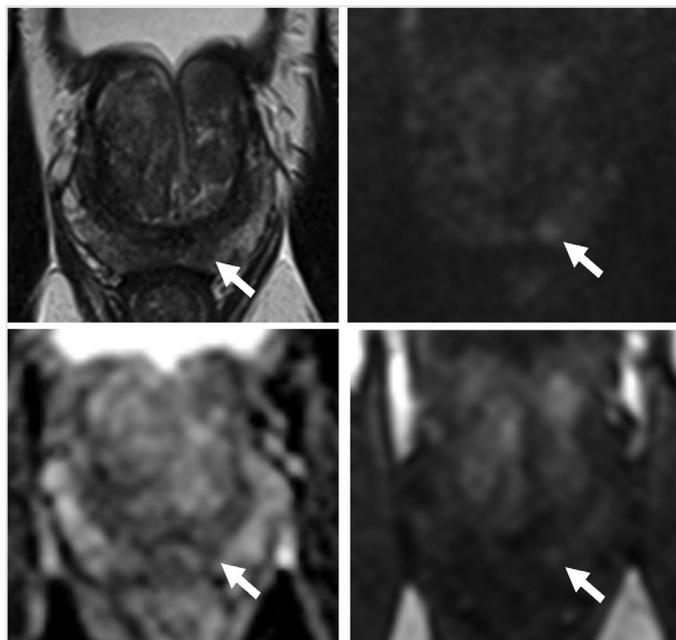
A 74-year-old patient with a PSA of 9.8 ng/mL, PSAd of 0.153 ng/mL/cm³, and mpMRIs from a to d; T2WI, DWI, ADC, and DCE, respectively. An 9 mm lesion localized on the left mid-base peripheral zone (arrows). Reader 1, reader 2, and consensus PI-RADSv2.1 scores were 2, 3, and 3, respectively. TRUS systematic biopsy revealed an ISUP 1 tumor with 5% involvement in the relevant core
